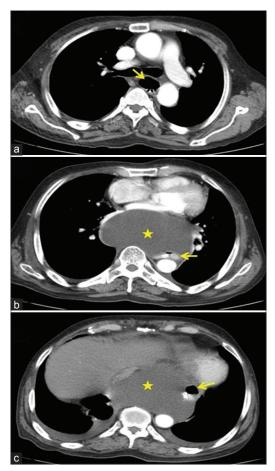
(a-c) Axial sections of contrast enhanced multidetector computed tomography scan of the chest showing a posterior mediastinal lesion (star) with fluid attenuation causing lateral displacement of the oesophagus with Ryle's tube *in situ* (arrow)
